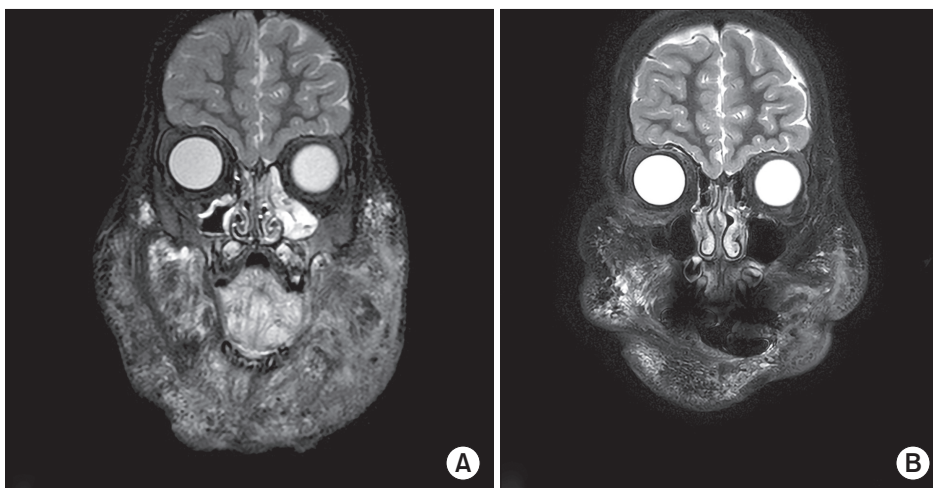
Coronal T2-weighted MRI of a patient. (A) At the beginning of therapy. (B) At 1 year of sirolimus therapy.
